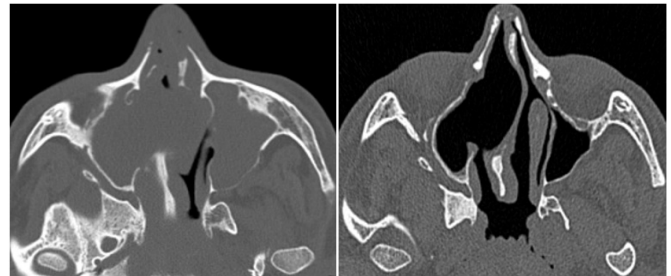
A 40-year-old white male. Fig. 5. The control CT scan one week after the surgical intervention. Destruction of the medial wall of the right maxillary sinus and an ethmoid labyrinth on the right, and displacement of the median structures sharply to the left.
